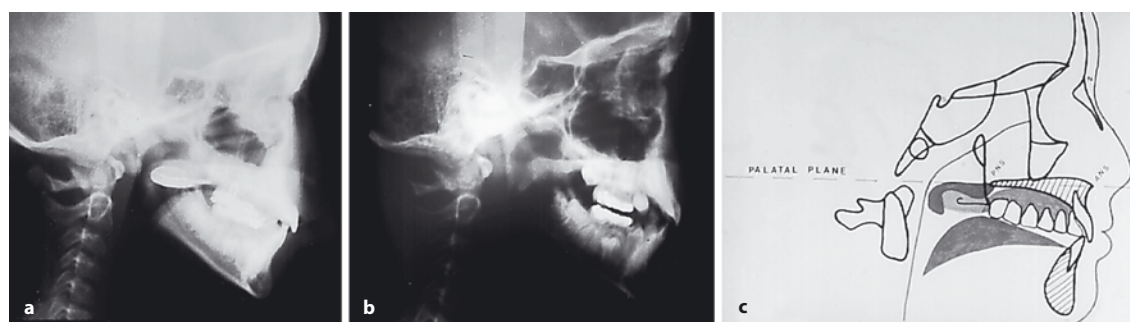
a Radiographic view of the palatal lift prosthesis of patient in Fig. 18.2 in position. Note the degree of palatal elevation. b Increased mobility of the soft palate after 1 year of prosthetic stimulation. Pharyngeal flap surgery was done after
